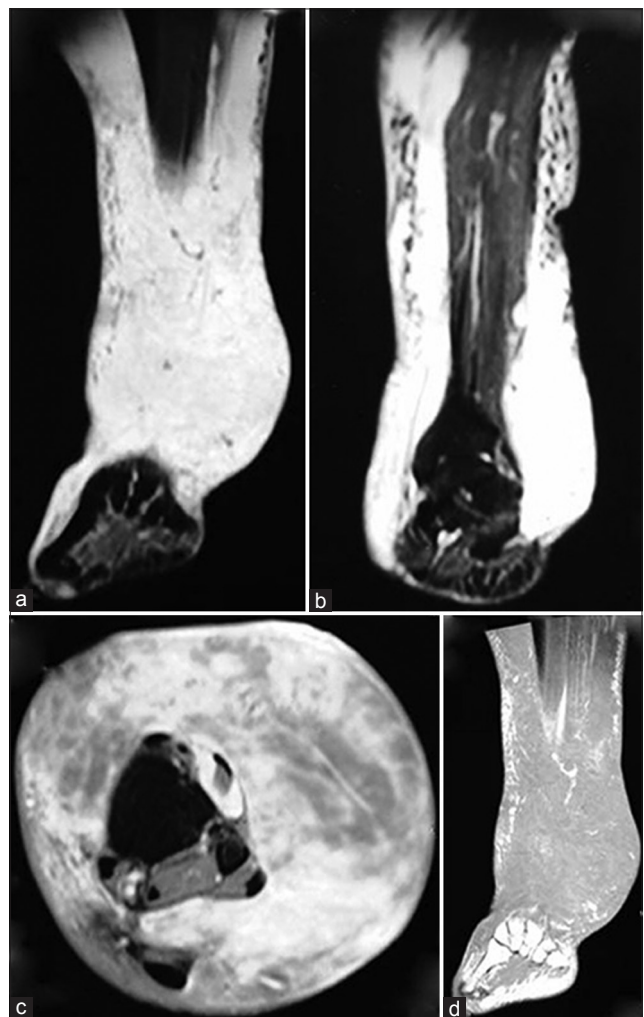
Magnetic resonance imaging (a and b) Short tau inversion recovery coronal, (c) postcontrast T1 axial and (d) T1 coronal images showing nonencapsulated intense homogeneously enhancing soft tissue mass infiltrating within subcutaneous and cutaneous planes of left lower leg
